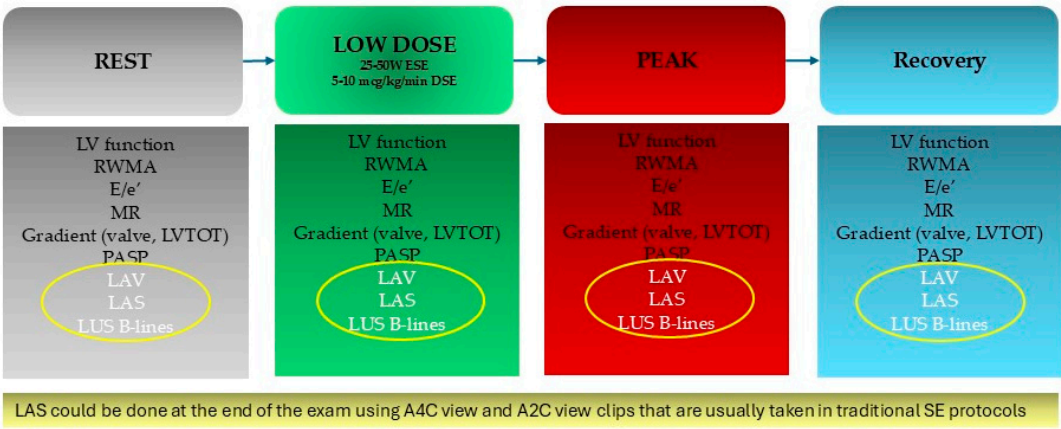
Stress Echocardiography protocol includes evaluation of left atrial function and pulmonary congestion. A2C: apical 2-chamber; A4C: apical 4-chamber; DSE: dobutamine stress echocardiography; ESE: exercise stress echocardiography; LAS: left atrial strain; LAV: left atrial volume; LV: left ventricle; LVOT: left ventricle outflow tract; LUS: lung ultrasounds; MR: mitral regurgitation; PASP: pulmonary artery systolic pressure; RWMA: regional wall motion abnormalities; SE: stress echocardiography.
